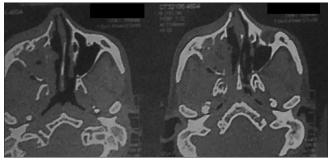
CT PNS showing disease in left maxillary sinus with bony erosion
